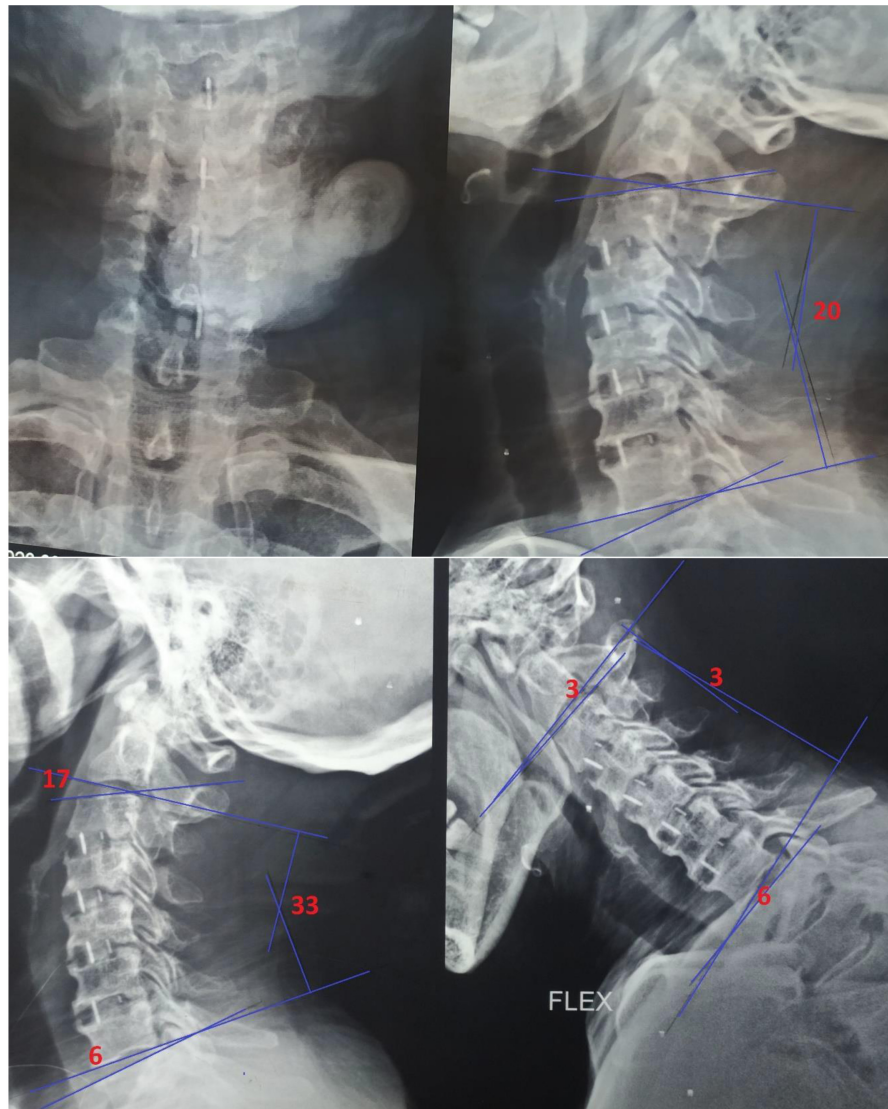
6 months Postoperative X-ray Cervical spine flexion, extension, A-P and lateral views global lordosis was 20 and global ROM increased to 36 (33 for extension and 3 for flexion). Cranial ROM increased to 20 (17 for extension and 3 in flexion).
